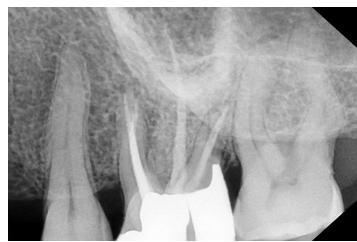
Three-Month Follow-up Radiographs.
